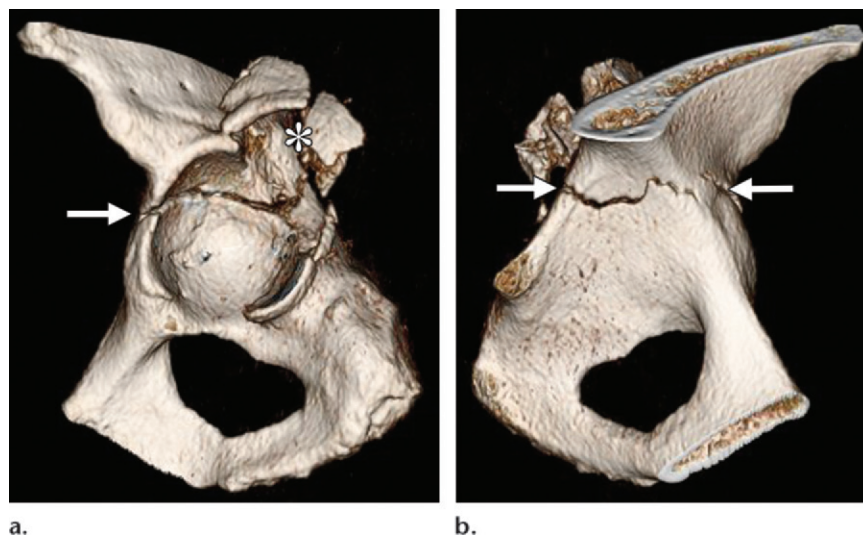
Transverse with posterior wall acetabular fracture in a 54-year-old woman. Lateral (a) and medial (b) 3D surface-rendered CT images show a transverse acetabular fracture (arrows). A displaced comminuted posterior wall fracture (* in a) is also seen.
